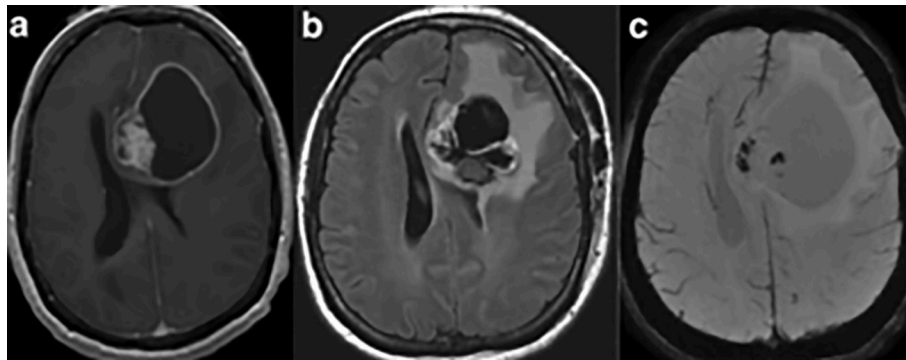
Cystic Meningioma of Falx Cerebri (Grade 3 According to WHO Classification): a) T1; b) FLAIR; c) Susceptibility Weighted Sequence Revealing.
